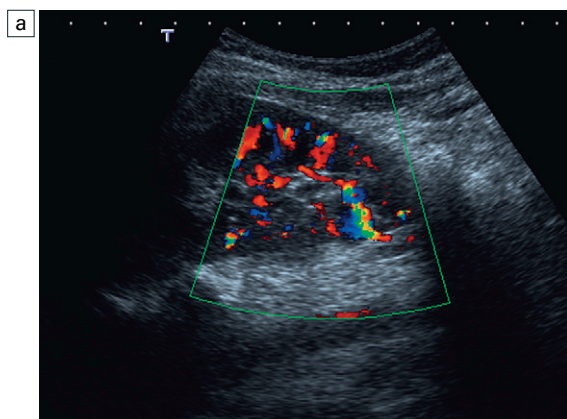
(a) Coronal colour flow Doppler image of the lower pole of the left kidney. An unusual vessel is demonstrated at the lower pole. (b) Reducing the colour sensitivity the polar vessel is more clearly identified.
